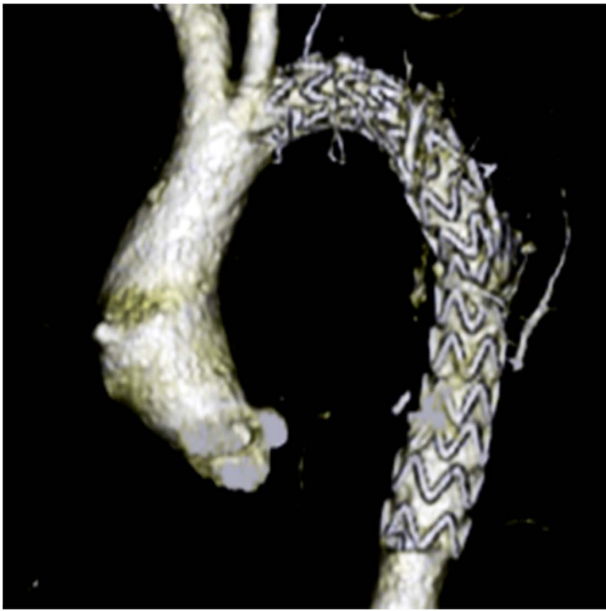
Postoperative computed tomography scan showing the successful stent graft placement with no migration or endoleak. The aneurysm had already been thrombosed.
